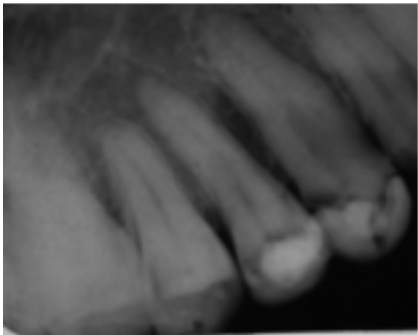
Earlier Radiographic Image (Diagnosis) tooth14
